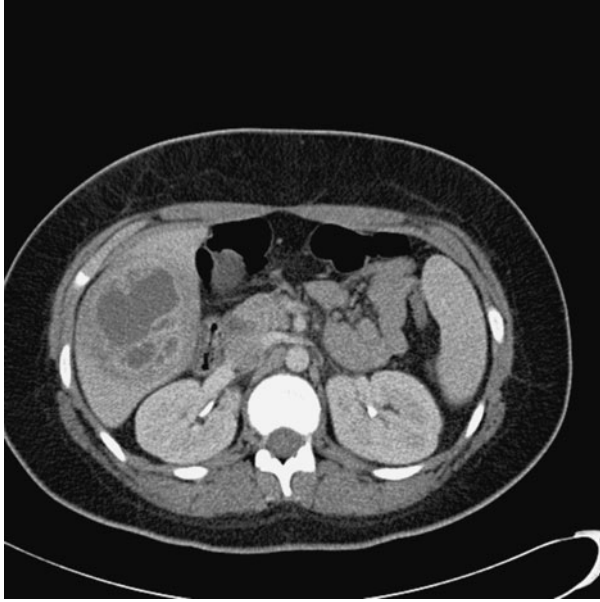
Computed tomography abdomen of a 12-year-old girl with a post-appendicitis right lobe liver abscess.
